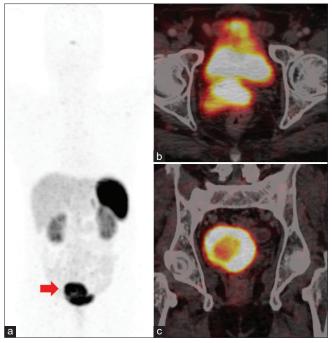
Ga-68- DOTANOC PET/CT: MIP shows intense SSTR uptake in pelvic region (a). Corresponding fused transverse and coronal images show large soft tissue mass involving prostate & seminal vesicle with intense SSTR expression (b,c)
